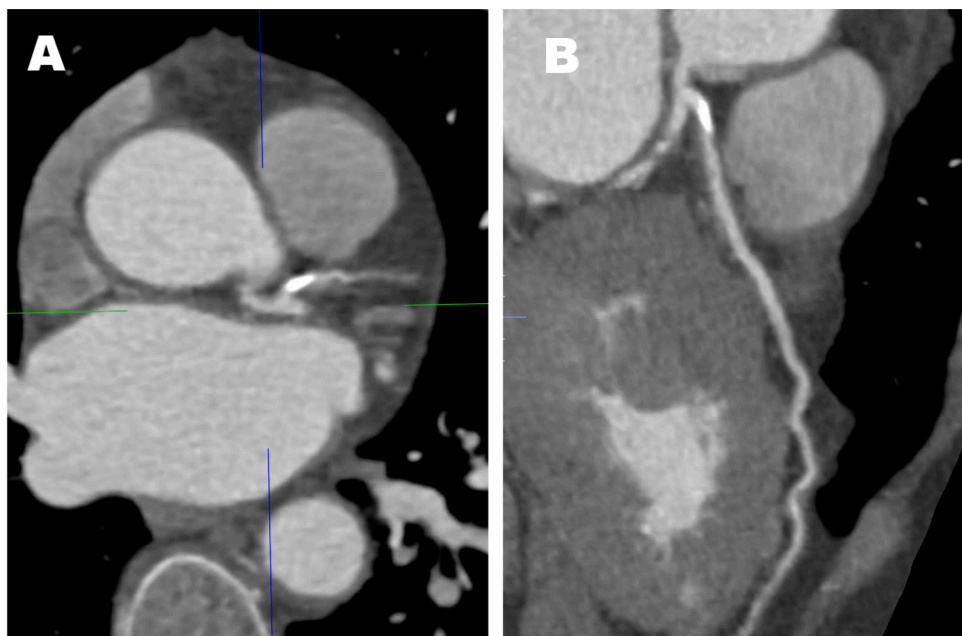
Computed tomography coronary angiography of calcific lesion seen in Figure 2.
